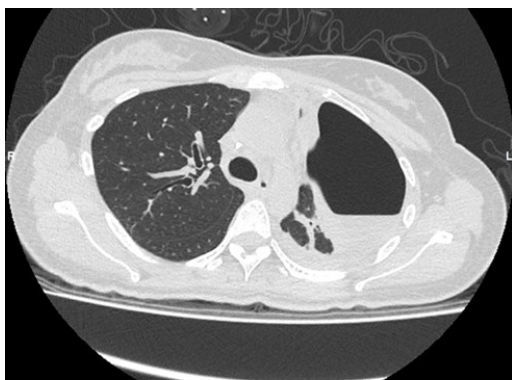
CT image in lung window demonstrate air fluid level in left hemithorax suggestive of hydropneumothorax with adjacent collapsed lung.
